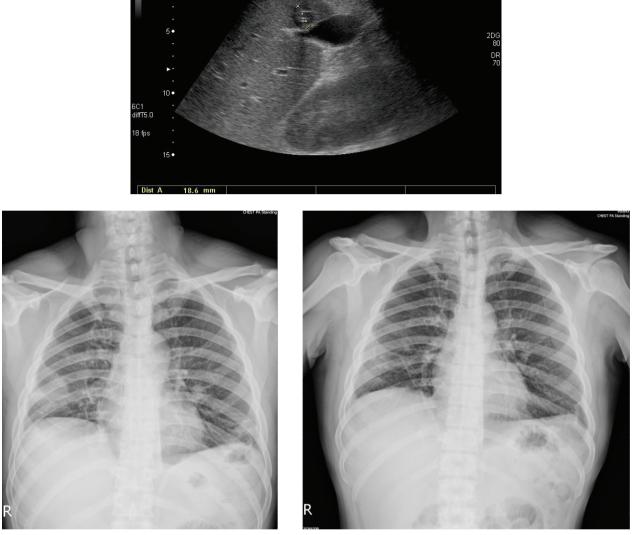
Abdominal sonography 1 month after pigtail drainage (upper column), which showed decreased diameter of the abscess (18.6 mm), and chest plain film 1 month (lower left column) and 2 months (lower right column) after initiating antimicrobial treatment.
